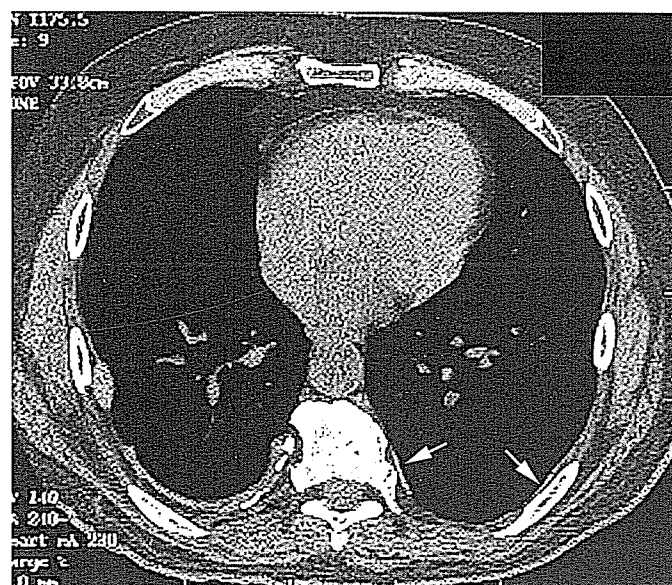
A 68-year-old man with asbestos related pleural plaques. CT shows bilateral plaques. The plaques on the right are easy to recognize because they are elevated and the more medial plaque is partly calcified. The linear plaques on the left (arrows) are more subtle; the more medial plaque is recognizable because it is hyperdense, while the more lateral plaque is distinguishable from intercostal muscles because it overlies a rib.
